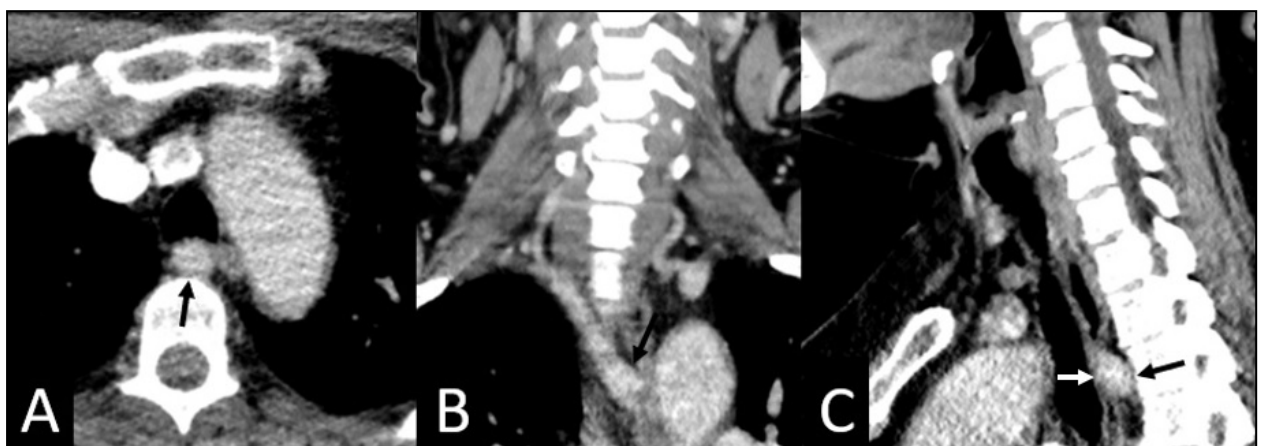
Contrast-Enhanced CT Neck demonstrated an anomalous right subclavian artery (black arrows) with extrinsic compression of the cervical esophagus (white arrows). A, axial view; B, coronal view; and C, sagittal view.
